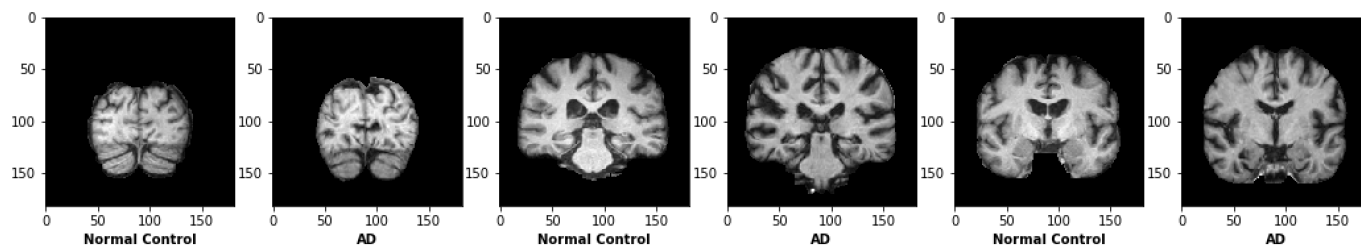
Examples of three pairs of slices from the normalised MRI volumes we use for Alzheimer's patients and normal controls.
